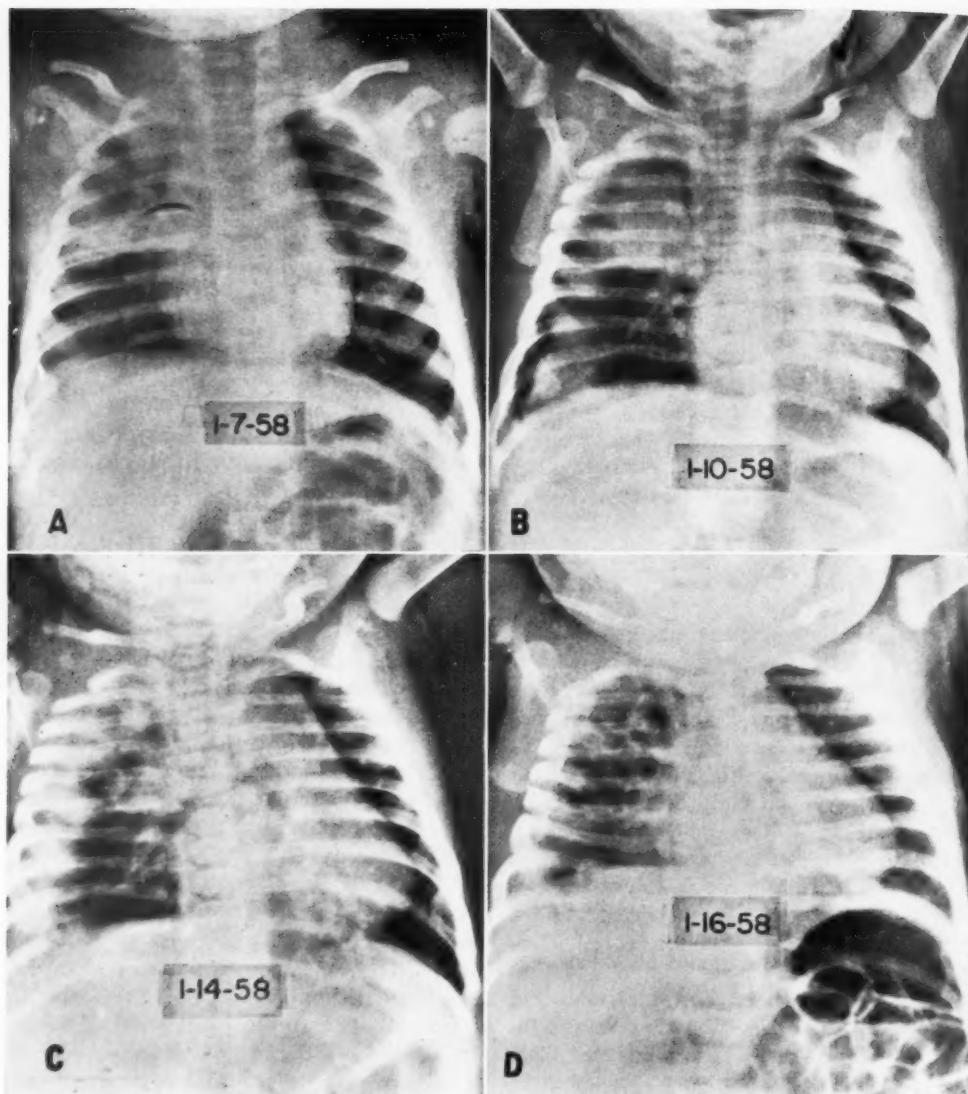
A. Only infiltration is seen in the first roentgenogram of a three-month-old infant.
